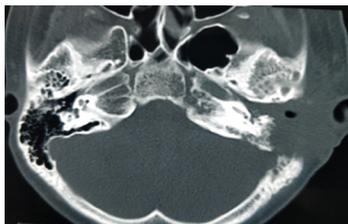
HRCT Temporal bone axial cuts showing large heterogeneously enhancing soft tissue density in left ear involving mastoid, middle ear and external auditory canal
